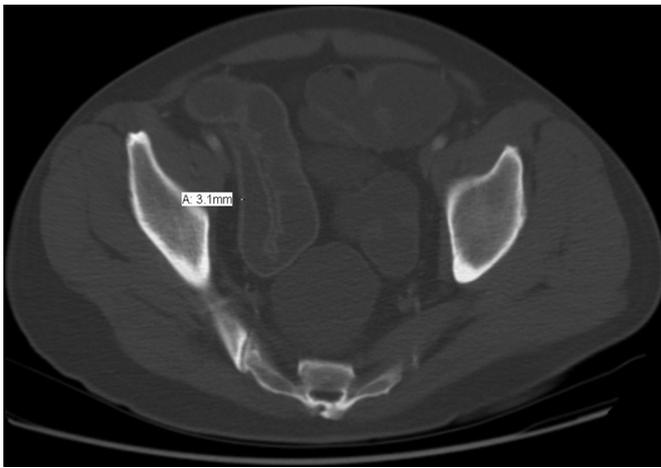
Abdominal/pelvic computed tomography with contrast showing diffuse dilatation and edema of the small bowel consistent with but not specific for AIE.
